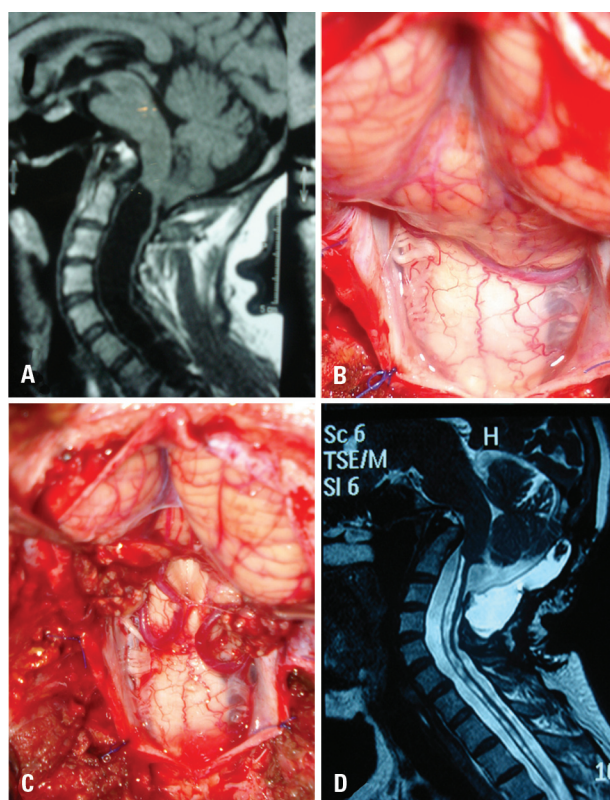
[A] Preoperative MRI depicting a large syringomyelic cavity without tonsillar herniation. [B] Tonsillar herniation and dilation of the medulla. [C] Tonsilectomy and large opening of the fourth ventricle. [D] Reduction of the syringomyelic cavity, creation of a large cisterna magna, and pseudomeningocele.
